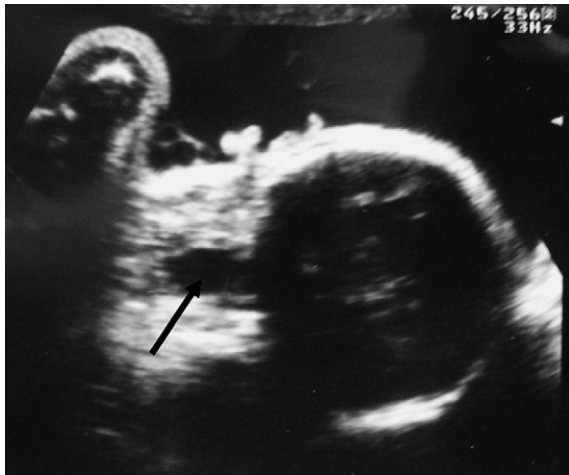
Antenatal ultrasound scan (34 weeks gestation): lateral view demonstrating the cyst (arrow) behind the tongue, in the upper aero-digestive tract.
